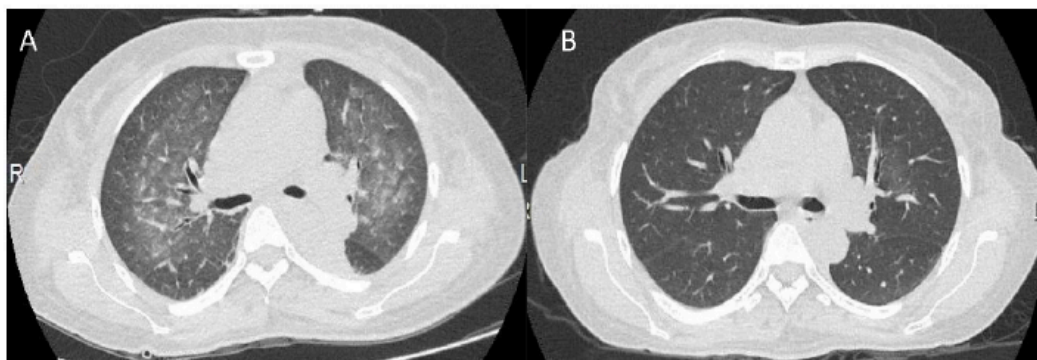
Chest computed tomography (CT) images. The images were obtained at the time of admission (A) and after one month of treatment (B).
